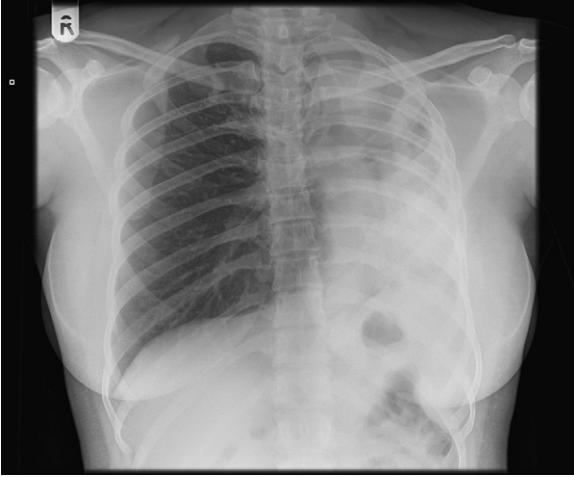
Plain chest radiograph showing left hemithorax whiteout with signs of left sided volume loss and deviation of mediastinal structures.
